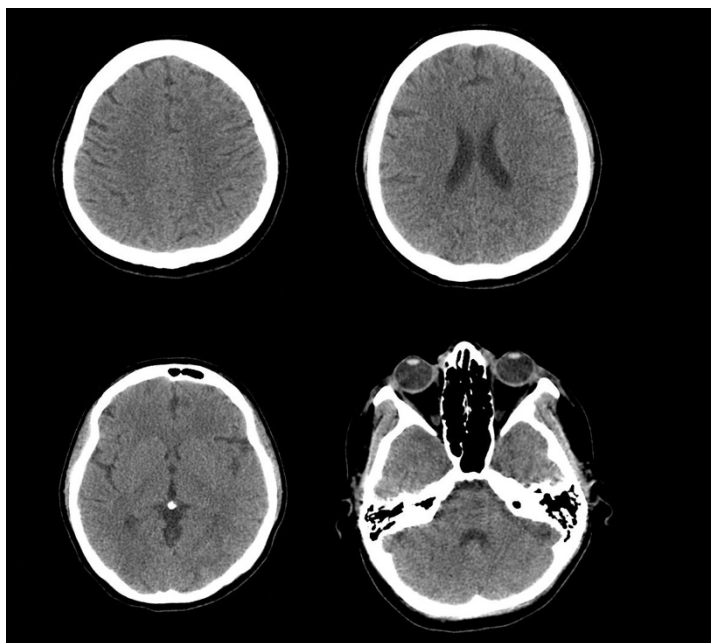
There was no cerebral hemorrhage seen in the non-enhanced computed tomography scans
